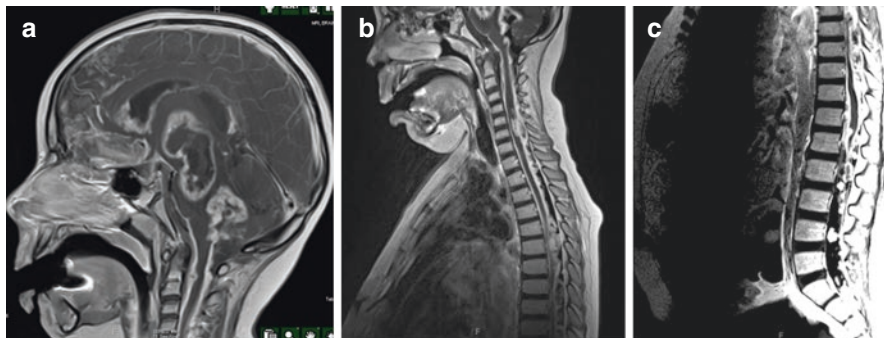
Disseminated Glioblastoma. Different MRI T1 after gadolinium injection in sagittal cuts of brain (a), cervical and upper thoracic spinal cord (b), and thoraco-lumbar area (c)
